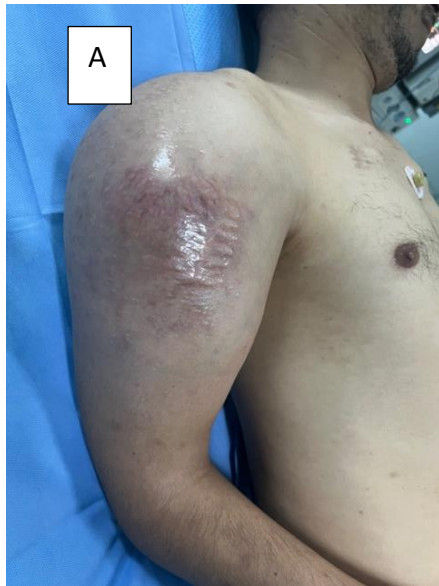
A: Clinical case, Y.Z., a 34-year-old patient, admitted to our department for the management of a rapidly evolving malignant-looking tumor mass at the upper end of the right humerus. B: MRI image of the same mass.
